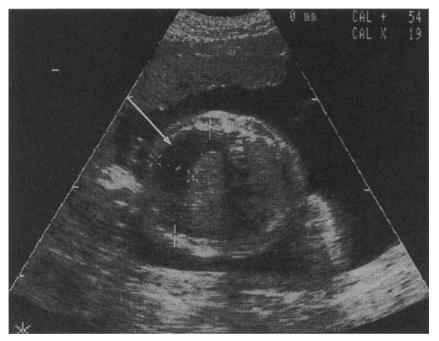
Sonogram of the thorax at 28 weeks of gestation. Note the large, right pleural effusion (arrow)
